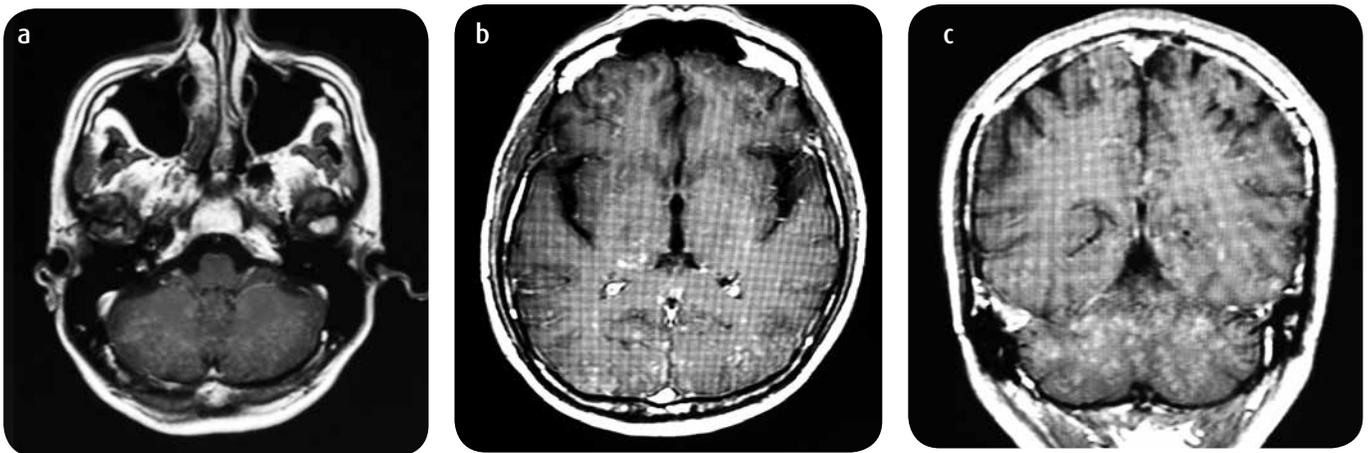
MRI sequence with T1 information with contrast medium: a and b) axial sections and c) coronal reconstruction, showing small foci of subcortical nodular enhancement supra and infratentorial, without white matter edema or meningeal enhancement.
